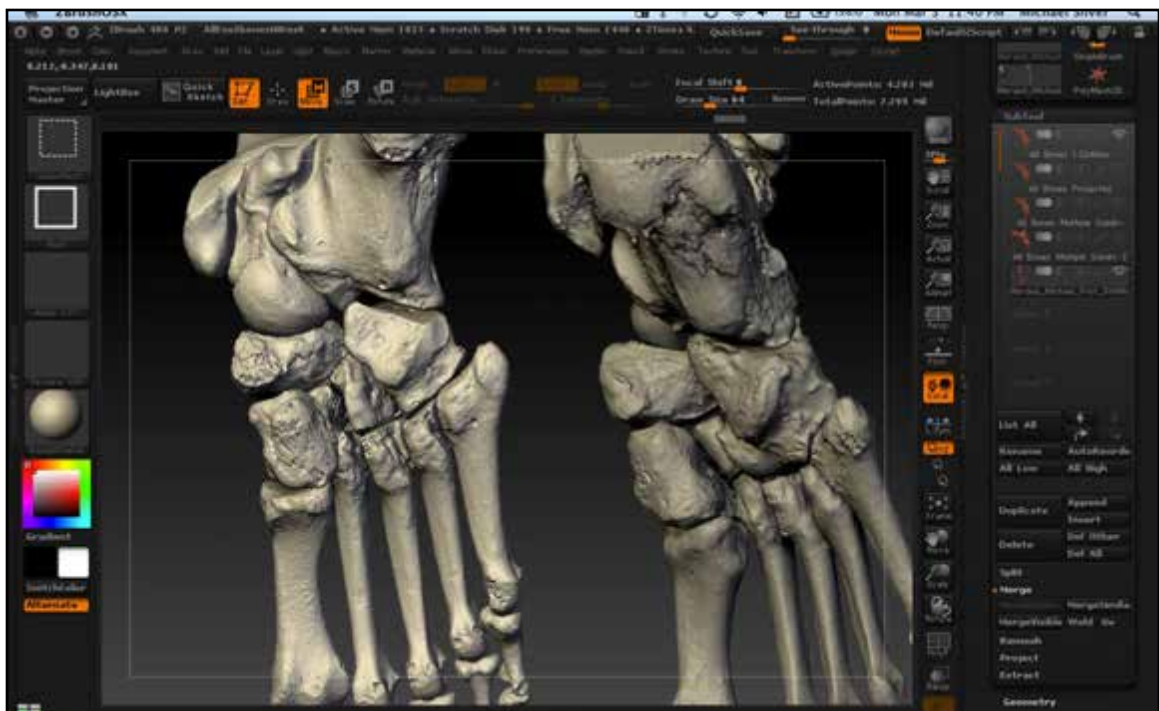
Laser scan data mesh (left) CT based mesh (right).
